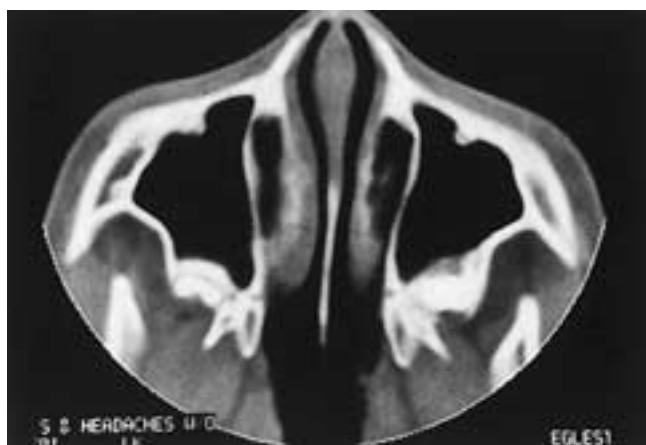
Normal nasal cavity in a 13-year-old child. Axial CT scan of a normal nasal cavity in a child is similar in appearance to that in an adult, with the nasal septum wider at its anterior portion, slightly concave lateral nasal walls, and a patent posterior choanae.
